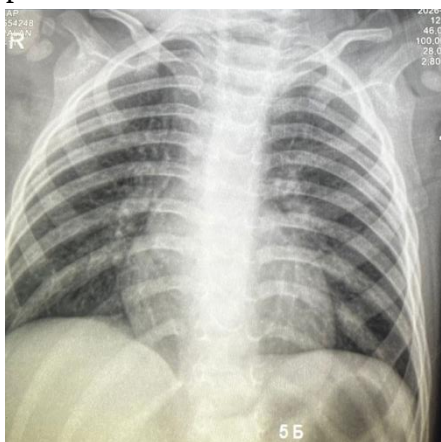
In Patient No. 5, chest radiography performed on day 3 of illness demonstrated radiological findings consistent with bilateral bronchopneumonia.
